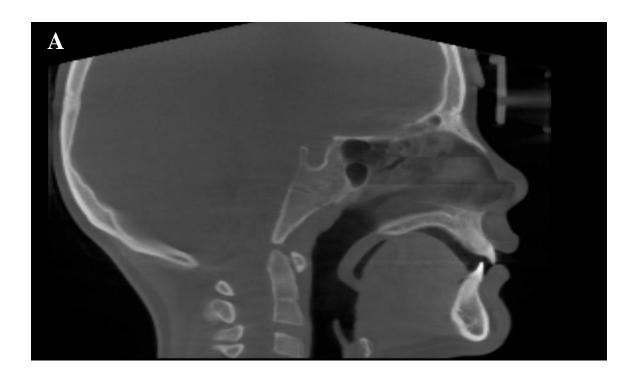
Pre-surgical (A) and post-surgical (B) CBCT scans demonstrating cross-sectional area at the level of PNS
